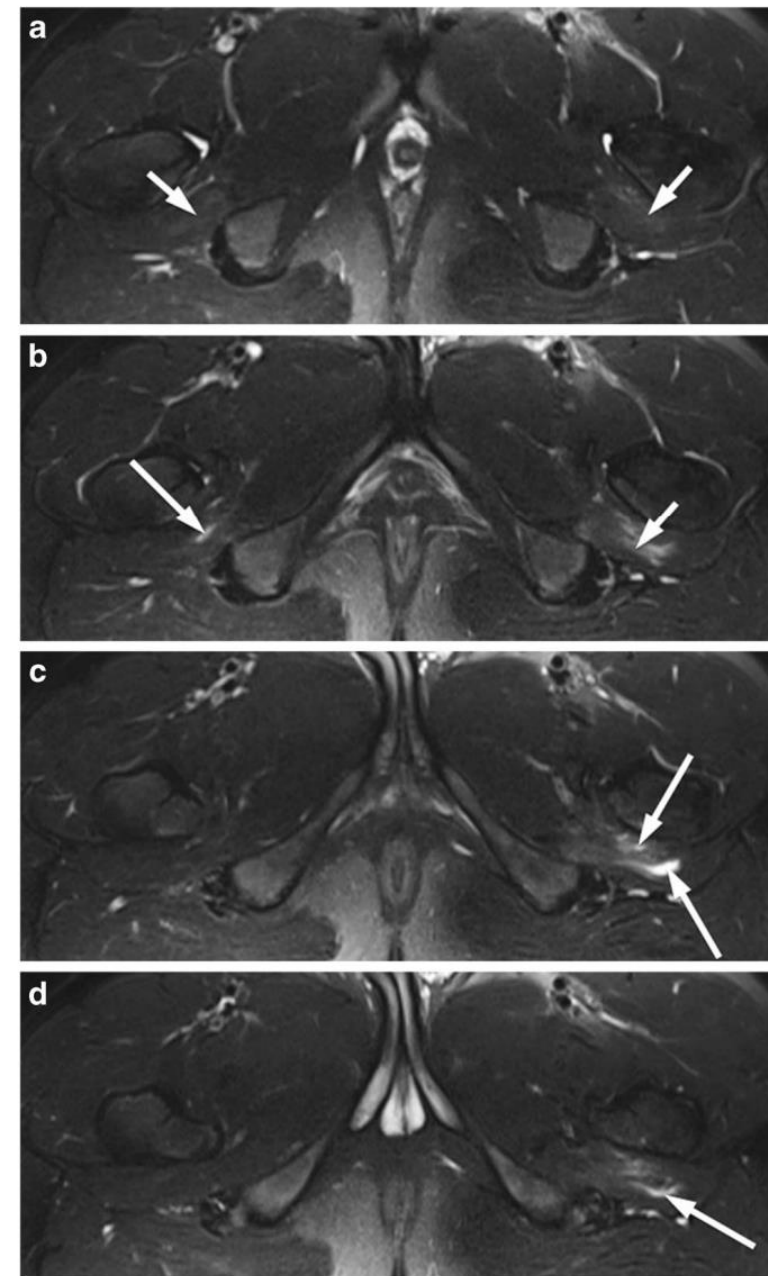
20-year-old man asymptomatic for hip pain. a–d. Consecutive axial T2-weighted (TR/TE, 4,300/92 ms) fat-suppressed FSE MR images show oedema (*short arrows*) and partial tears (*long arrows*) of the QF bilaterally, extending outside the IF space on the left (*c* and *d*)
